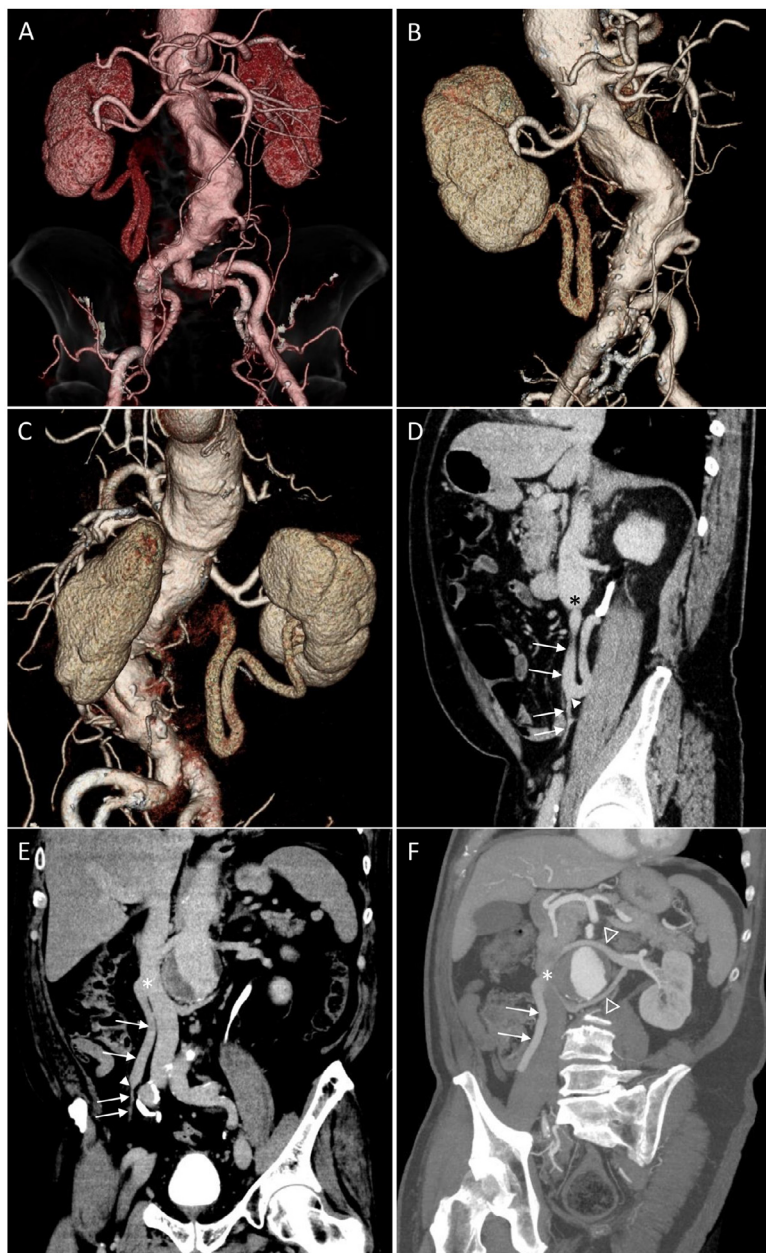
CT scanning. (A-C) Angiographic phase: coronal, oblique anterior view, oblique posterior view Volume rendering (VR) reconstructions; (D and E) urographic phase: parasagittal and paracoronar maximum intensity projection (MIP) reconstructions; (F) angiographic phase: paracoronar MIP reconstruction. Juxtarenal aortic aneurysm (A, B, E, F) with thick parietal thrombus (E and F). There is 1 renal artery per side (A). Two branches coming from right kidney hilum join to form 1 renal vein (C) that goes caudally until aortic carrefour level (A-C) and drains into the gonadal homolateral vein. In this point (D and E: full arrowhead), gonadal vein (B-F: arrows) shows an abrupt diameter increase, until its confluence into the inferior vena cava (D-F: *). Furthermore, duplication of left renal vein with circumaortic configuration is recognizable (F: empty arrowheads).
